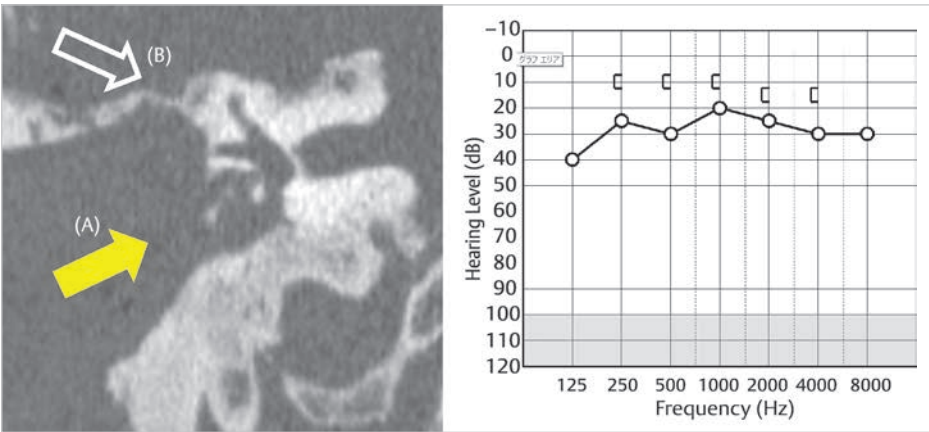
The CT conducted immediately postoperatively clearly demonstrates two approaches, transmastoid (a) and middle fossa (b). The hearing stays near-normal postoperatively due to preserved configuration of the tympanic cavity.
